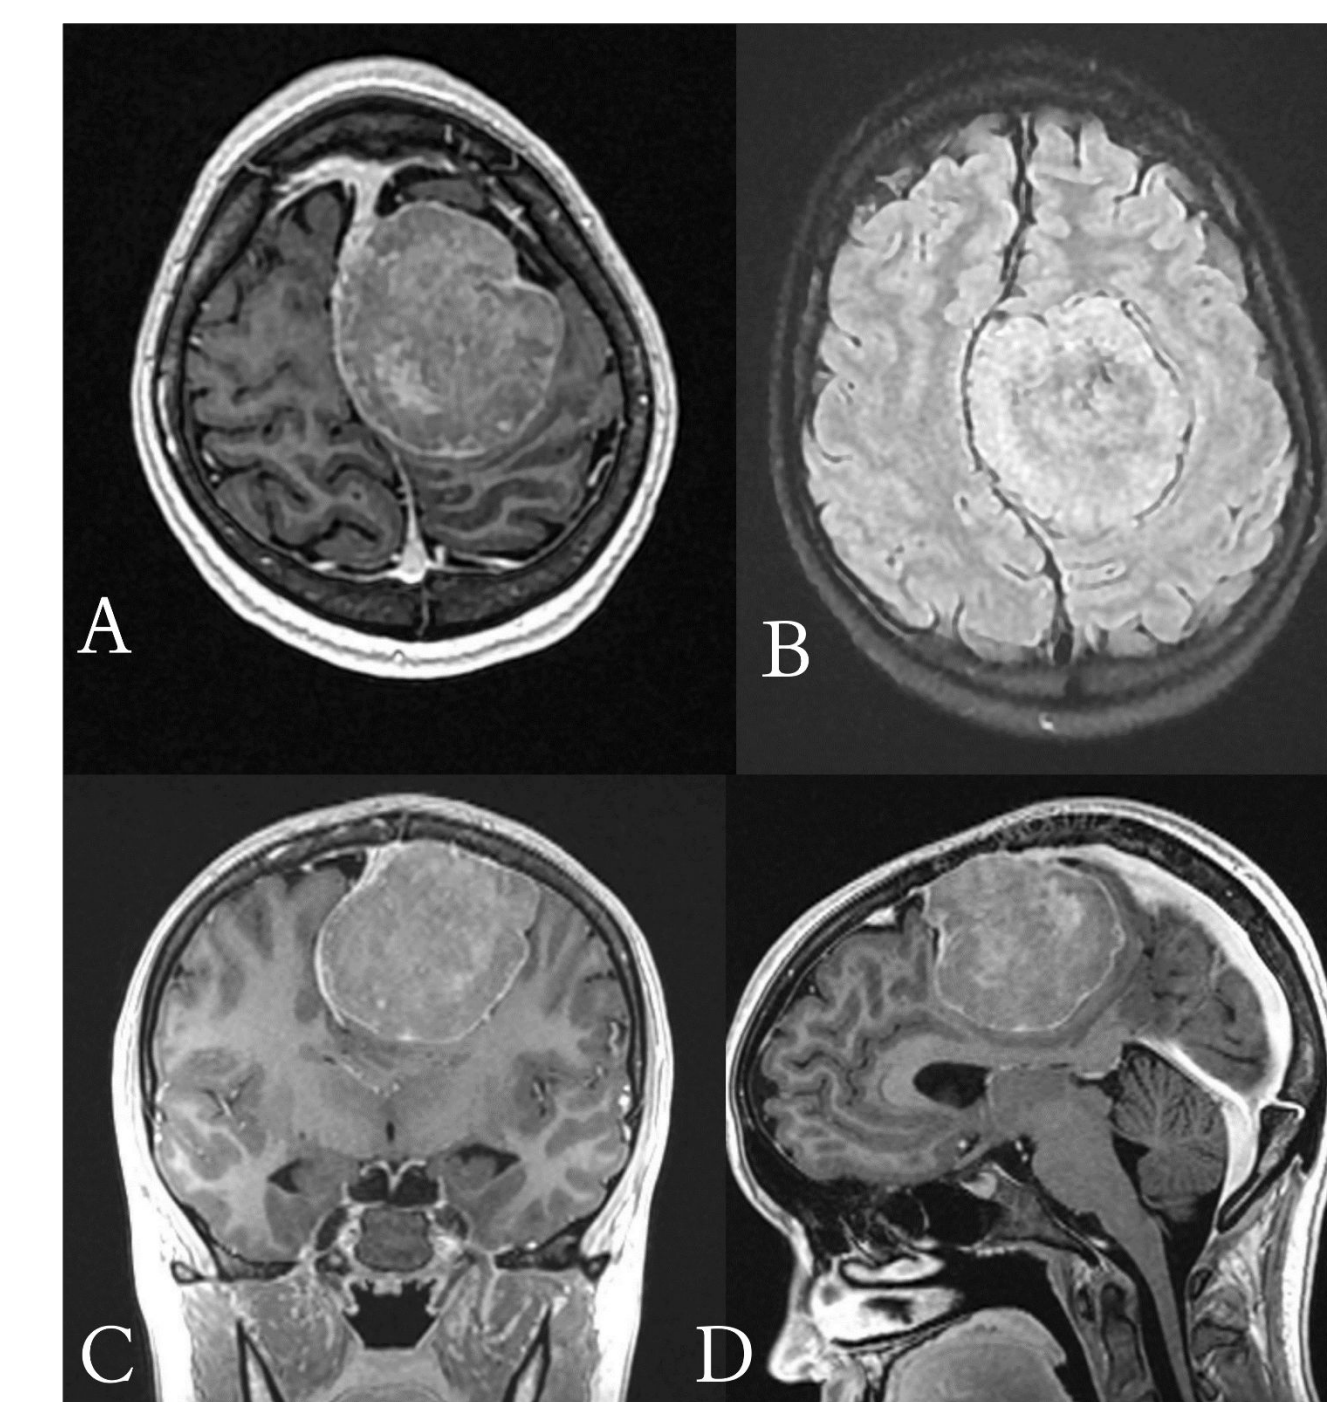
Magnetic resonance imaging (MRI) demonstrating a mass in the posterior frontal lobe, measuring 6.3cm x 6.7 cm x 6.2 cm (A-Axial T1 post-contrast) with minimal surrounding edema and midline shift (B-Axial T2 FLAIR non-contrast), with displacement of the falx and superior sagittal sinus of 2.2cm (C-Coronal T1 post-contrast), and downward displacement of corpus callosum (D-Sagittal T1 post-contrast).
